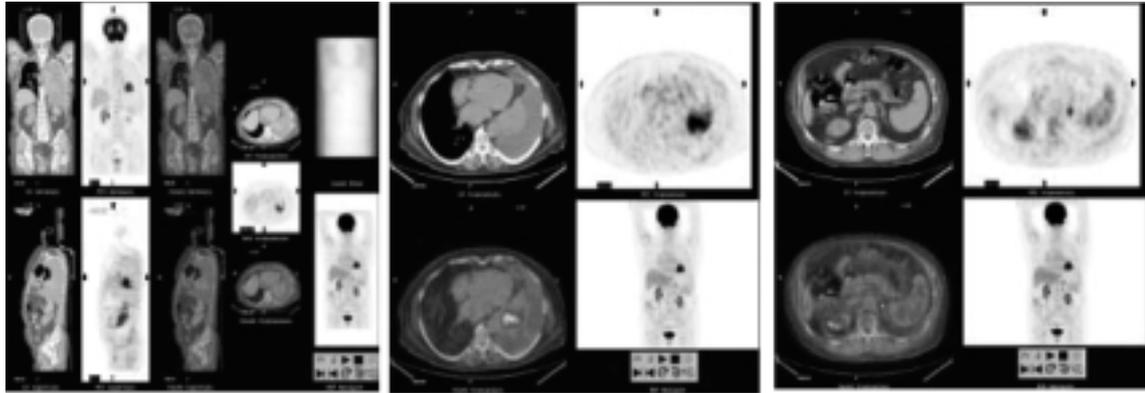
A 73-year old woman with a non-small-cell lung carcinoma (adenocarcinoma) of the left lower lobe with ipsilateral metastasis of the adrenal gland. No evidence for mediastinal metastases. (A) Full computer screen with CT, PET, PET/CT scans and maximal intensity projection (MIP) showing the extent of disease. (B) Transaxial CT, PET, and PET/CT scans showing the primary tumor and the pulmonary effusion. (C) Transaxial CT, PET, and PET/CT scans showing the metastasis of the left adrenal gland.
